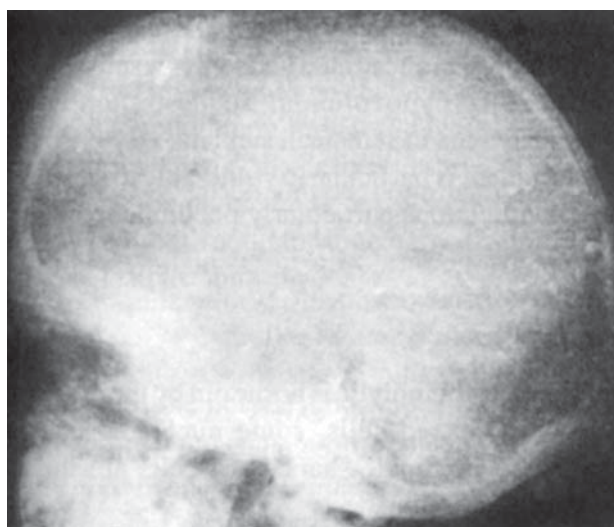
Thalassemia major. X-ray skull showing "hair-on-end" sign. This may be seen in other chronic hemoglobinopathies and chronic IDA as well.
